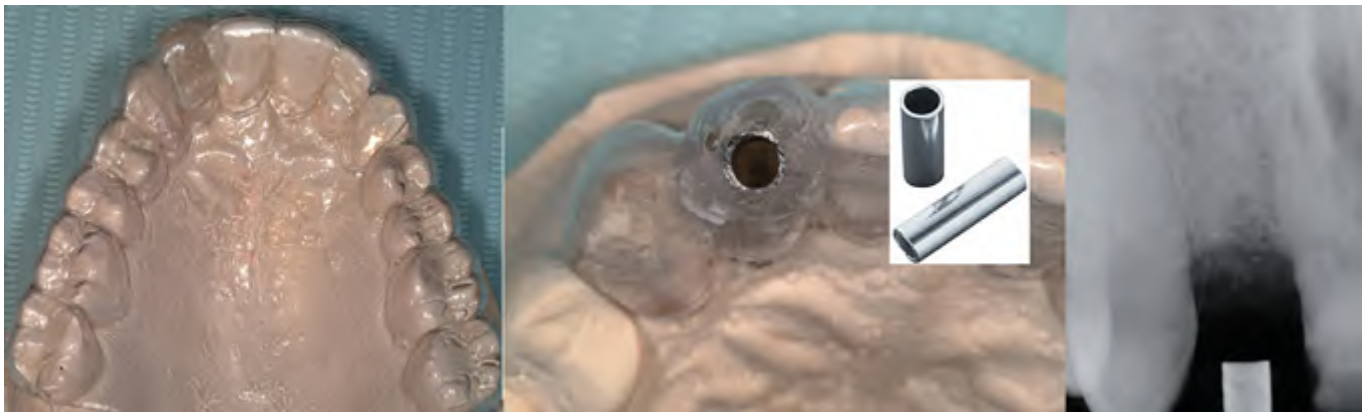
Laboratory occlusal view of the maxillary cast with the surgical guide in place (left). The periodontist placed the stent guide tube (SGT25; inset) into the surgical guide in a specific location based on the results of the clinical and radiographic examinations, as well as the optimal location of the planned implant restoration (center). Periapical radiograph of the maxillary right lateral incisor edentulous site with the surgical guide in place (right).
